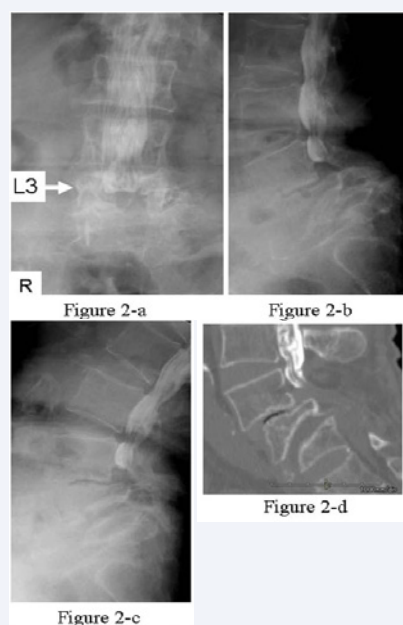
Myelographs showing a complete block at L3 level (2-a) and grade II slip of L3-L4 and grade I slip of L4-L5 (2-b, c). The reconstructed sagittal CT myelographs delineating the vertebral body of L4 showed a common wedged deformity, while that of L5 whose anterior wall height was diminished showed a reverse wedged deformity (2-d).
